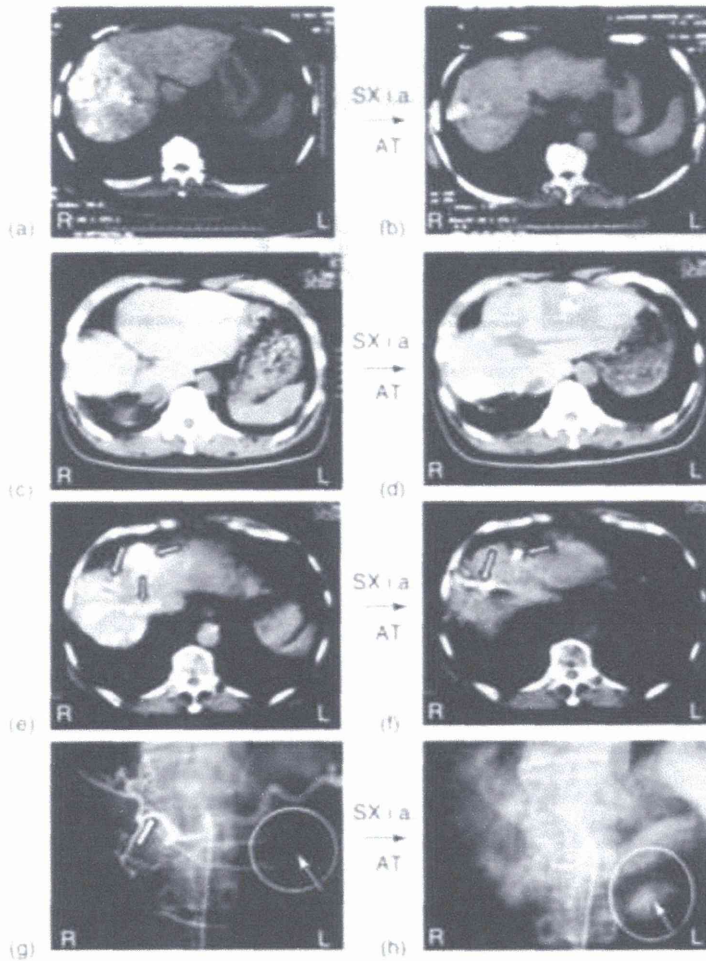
X-ray CT scan images of HCC either solitary/massive type (a and c) or recurrent case (e) with arterio-portal shunt. The figures show CT scan images of the malignant liver of the patients before and after arterial infusion of SMANCS/Lipiodol (SX i a) with concomitant angiotensin II (AT)-induced hypertension. In (a)–(f), white areas indicate tumors with SMANCS/Lipiodol retention as
